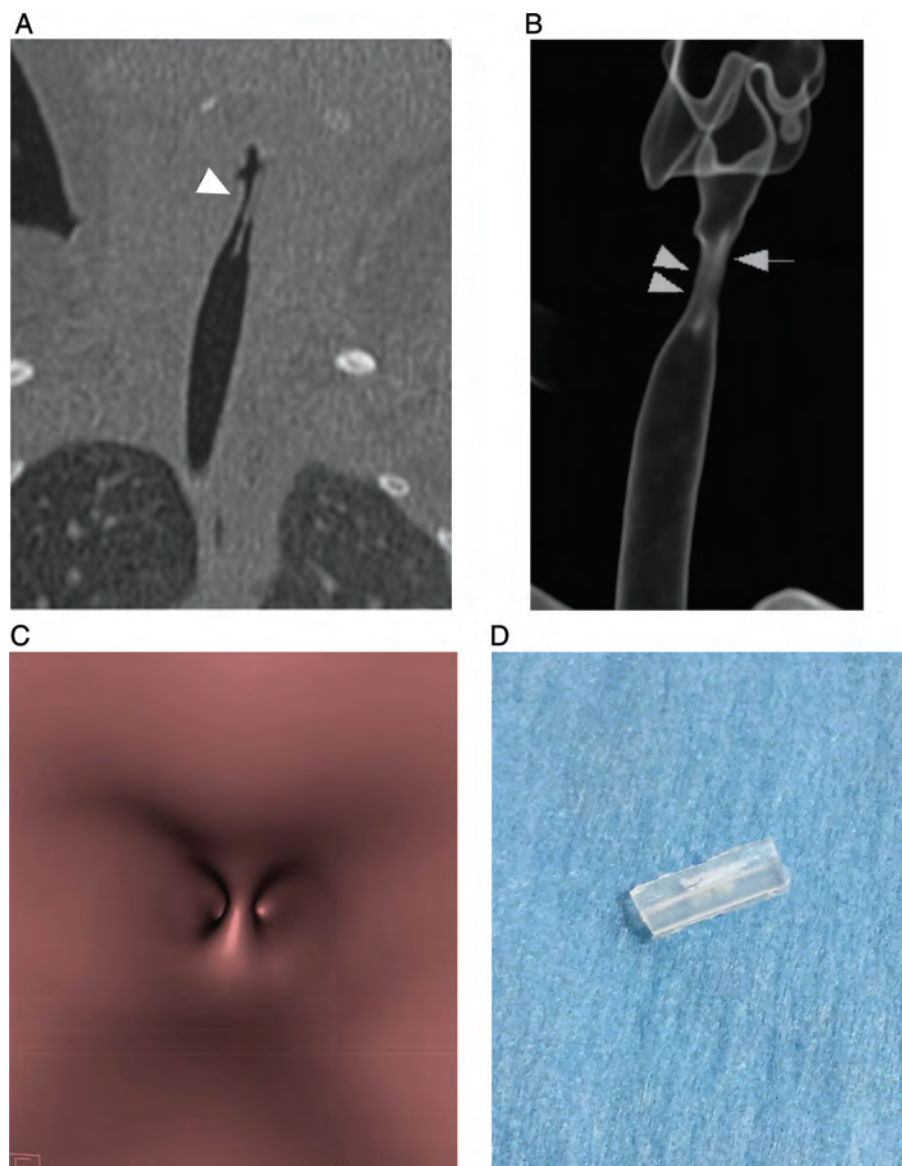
(A) Reconstructed coronal computed tomography (CT) image, displaying foreign body (FB) in glottis (arrowhead). (B) Three-dimensional volume-rendering technique (VRT) image with laryngography-like visualization, demonstrating FB (arrow) in glottic region (arrowheads). (C) Virtual bronchoscopic image with endoluminal surface view. (D) Piece of a toothbrush cover casing retrieved from larynx by laryngoscopy.
